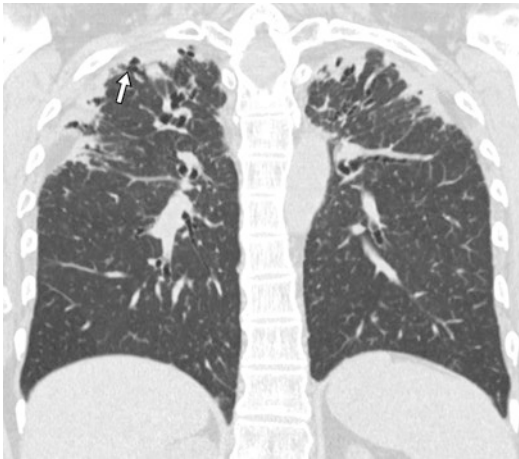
Pleuroparenchymal fibroelastosis in a 50-year-old woman with myeloblastic leukemia, 6 years after HSCT. Coronal CT shows biapical pleural thickening and subpleural fibrosis with traction bronchiectasis (arrow). Note associated upper lobes volume loss
